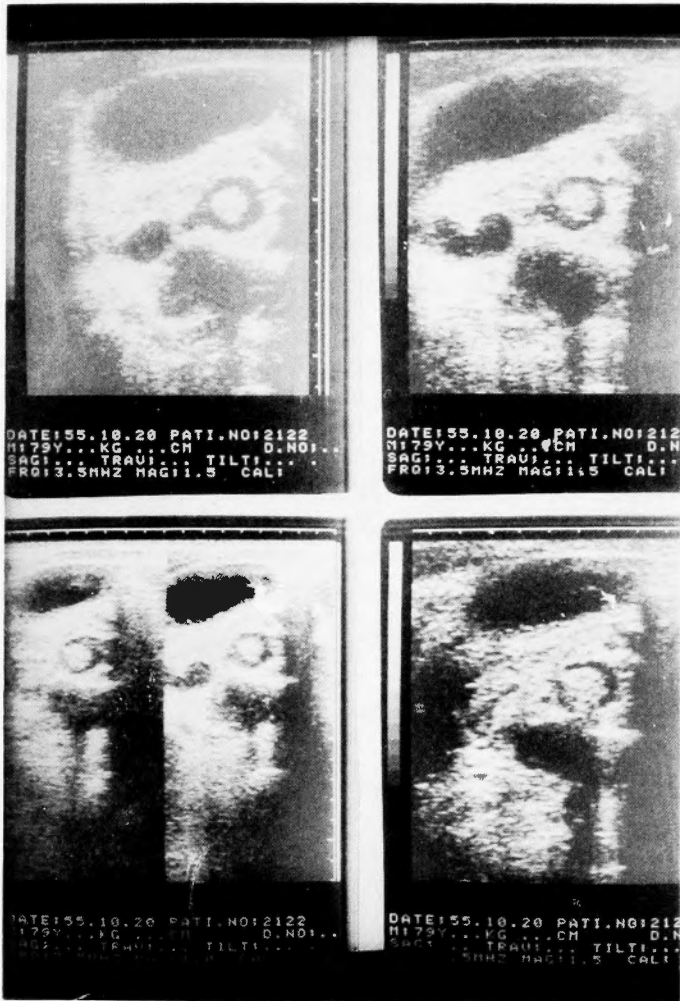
Ultrasound demonstrates the dilatation of gallbladder and choledochus. Choledocholithiasis was noted.
